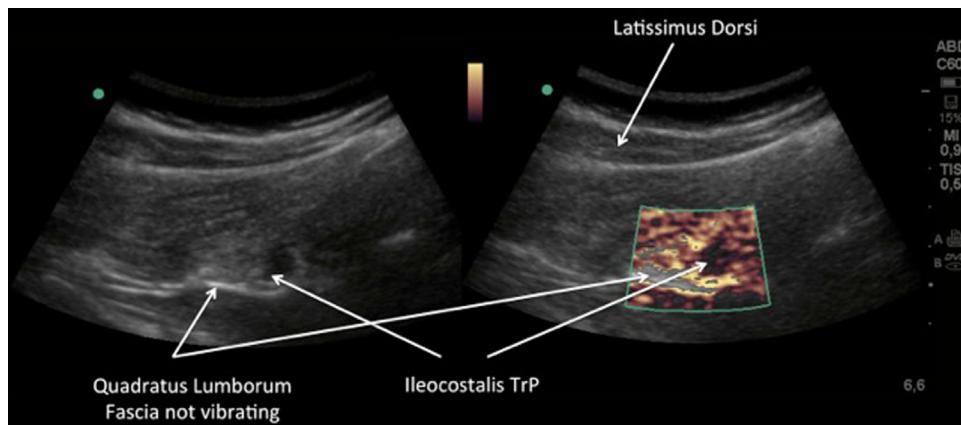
A hypoechoic rounded TrP is seen in the deep layers of the iliocostalis muscle. When vibration sonoelastography is applied in PW imaging, neither the iliocostalis TrP nor the fascia of the quadratus lumborum muscle shows vibration most probably because of focal stiffness. PW, Color Power Doppler.
